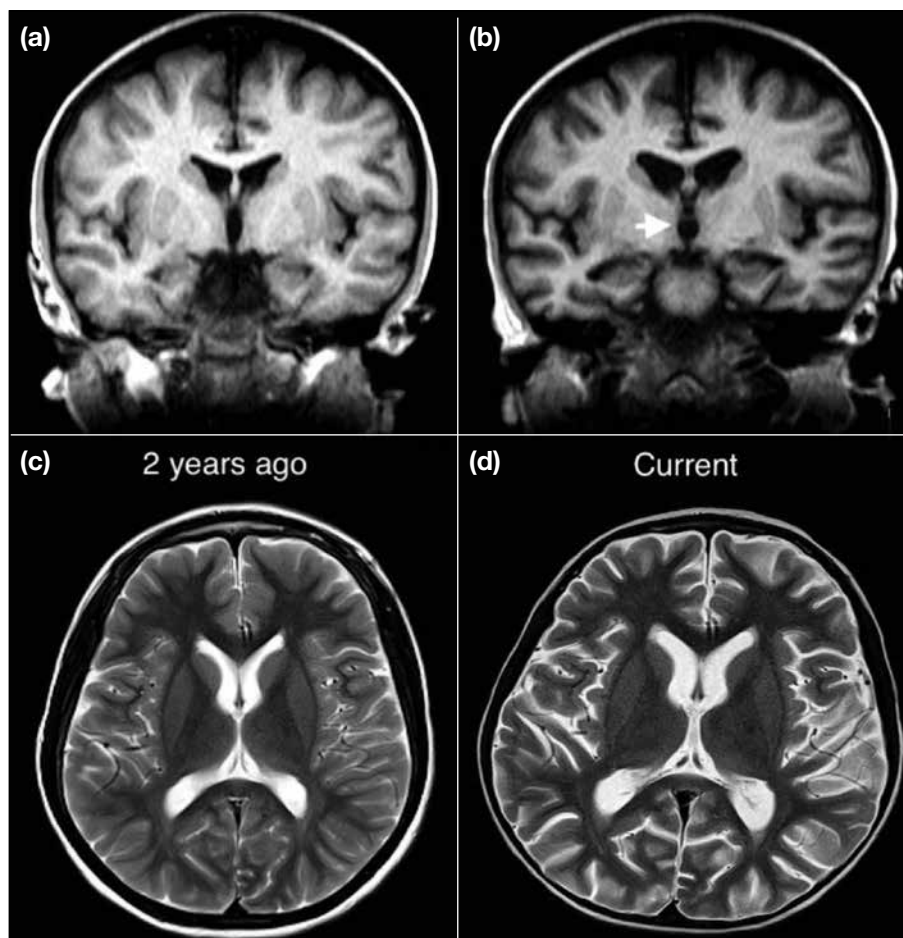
Comparison of magnetic resonance imaging 2 years apart in case 3. Features of chronic Wernicke's encephalopathy evidenced by interval neuronal loss at (b) bilateral thalami (note widening of third ventricle, short arrow) and mammillary bodies (as compared with [a]), as well as (d) generalised cerebral atrophy (note widened sulci and the Sylvian fissure; as compared with [c]).
